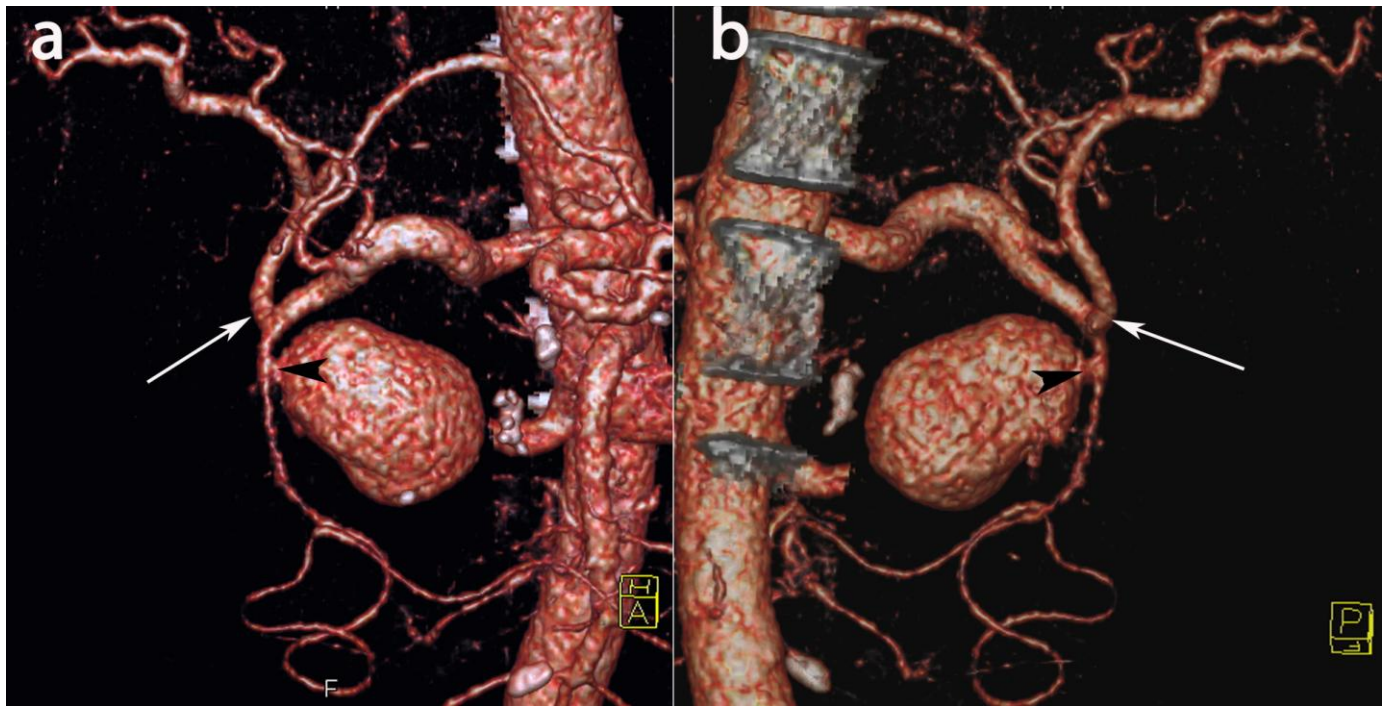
47 year-old male patient with abdominal pain. The volume rendering technique (VRT) of the contrast enhanced CT (arterial phase) in ventral (a) and dorsal (b) view demonstrate that the neck of the giant pseudoaneurysm (black arrow head) is very close of its outlet from the hepatic artery (white arrow) (protocol: 120 kV, 250 mAs, 150 ml Imeron 300, Altana, Germany).
